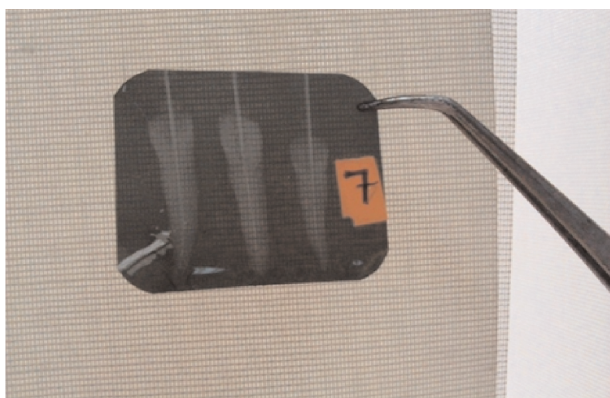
Determining the canal length from the x-ray image with a millimeter grid
